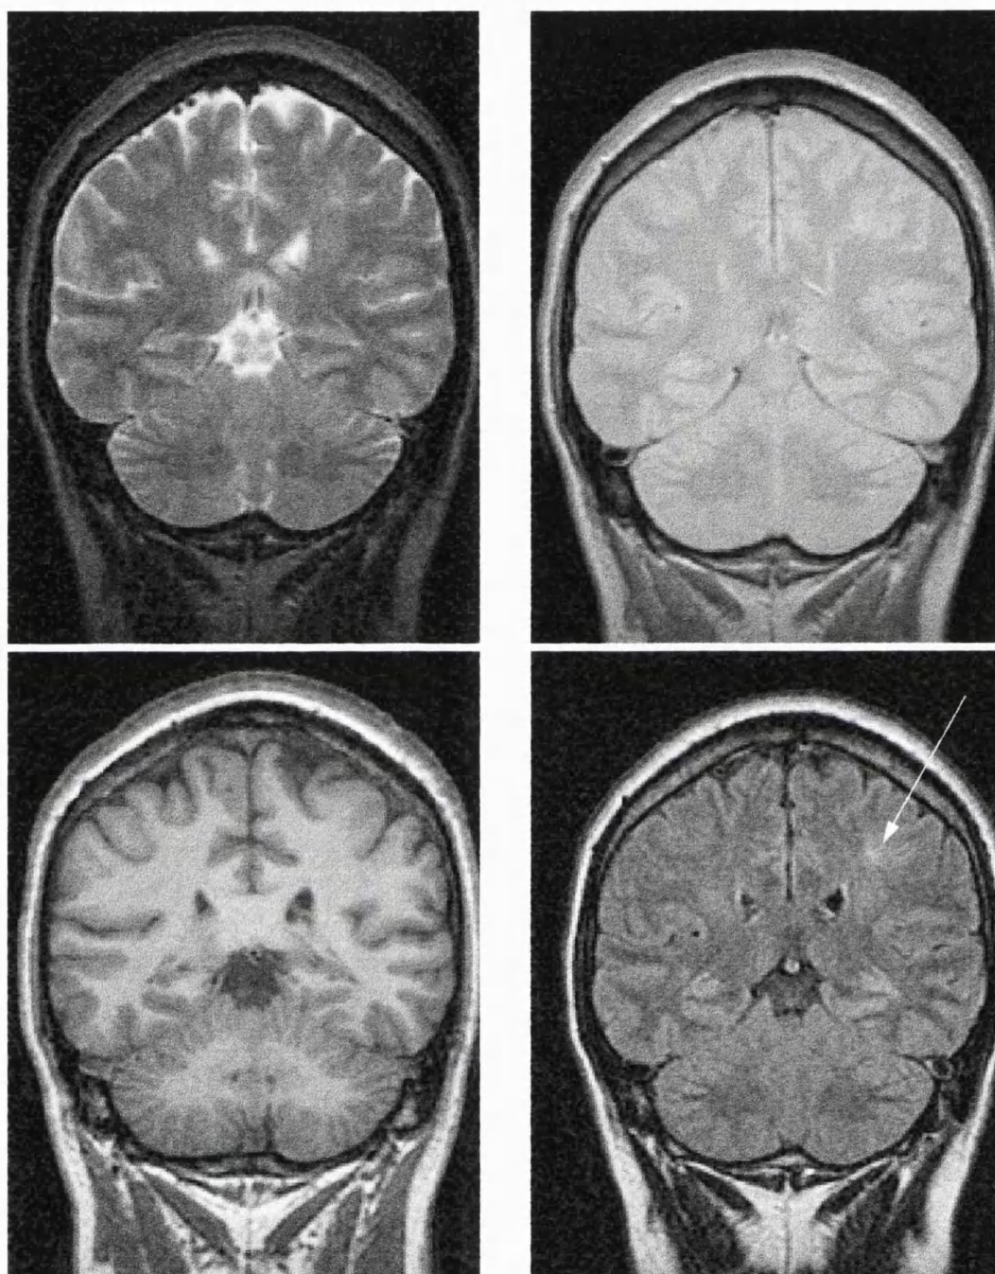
NORMAL STANDARD IMAGING. Coronal spin echo T2-weighted image (top left), proton density weighted image (top right), T1-weighted image (bottom left) and fast FLAIR image (bottom right). A small area returning a high signal is visible on fast FLAIR (arrow). Slight signal changes on the proton-density and T2-weighted images in this area are not clearly abnormal. The patient had frequent simple partial seizure with tingling on the right side, the EEG changes were in keeping with a left seizure focus.
